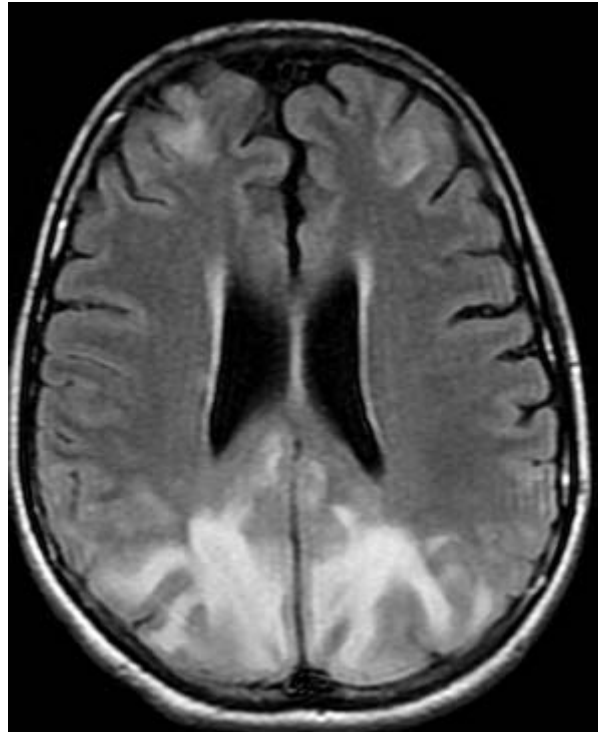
Brain MRI axial FLAIR sequence demonstrating bilateral symmetrical cortical and subcortical high T2 signal in the frontal and parietal lobes
